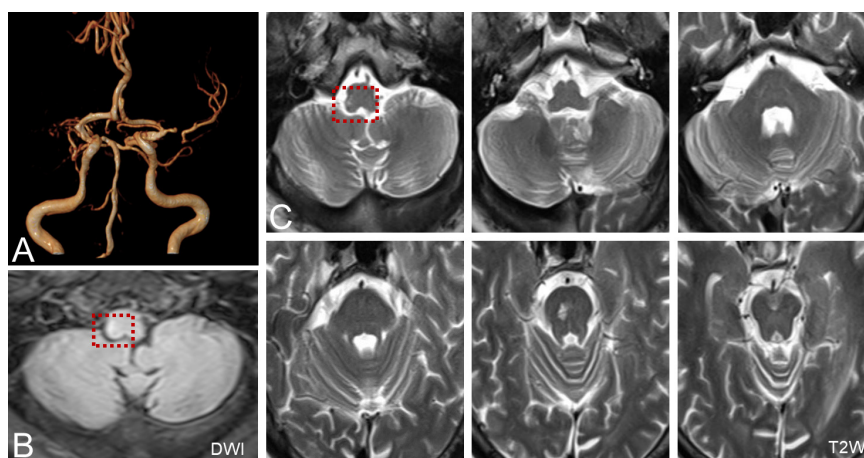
MRA and MRI of a patient with posterior circulation infarction. (A) MRA shows vertebral artery stenosis. (B,C) MRI shows acute infarction of the right medulla oblongata, which involved the ipsilateral vestibular nucleus (red dotted line frame).
